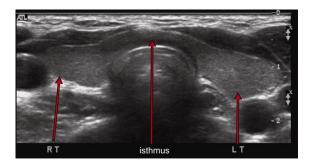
Thyroid ultrasound: Negative thyroid ultrasound exam. Multiple static images from real-time ultrasound of the thyroid gland were submitted without prior comparison films or reports. The thyroid gland appeared normal in size, configuration and echotexture. The right thyroid lobe (RT) size was 0.8x1.0x4.4 cm. The isthmus size was 0.3 cm AP. The left lobe thyroid (LT) size was 1.0x1.4x4.4 cm.
